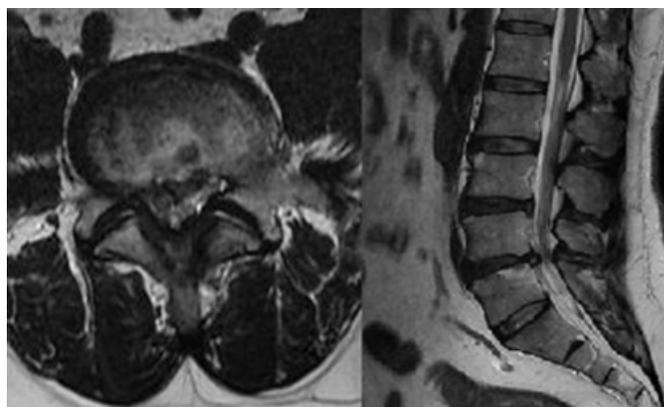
Magnetic resonance imaging (MRI) demonstrated an extruded L4–L5 disc on the right side in axial and sagittal T2-weighted MRI.
